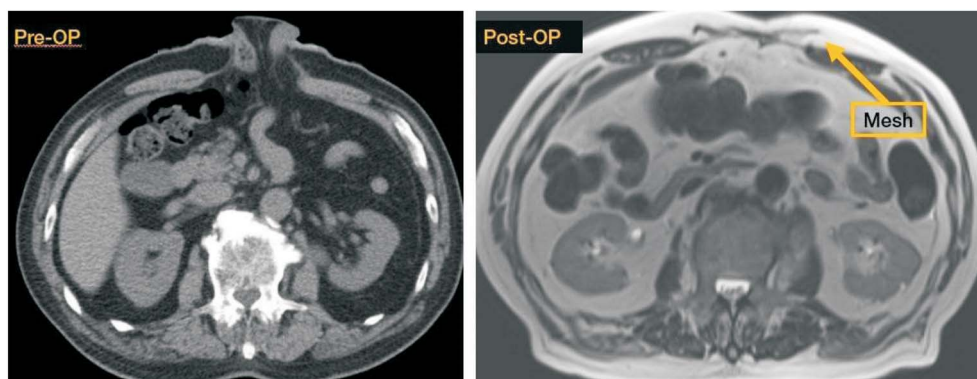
The development of an incisional hernia was detected in at least 6-month follow-up period by CT scan or MRI.
